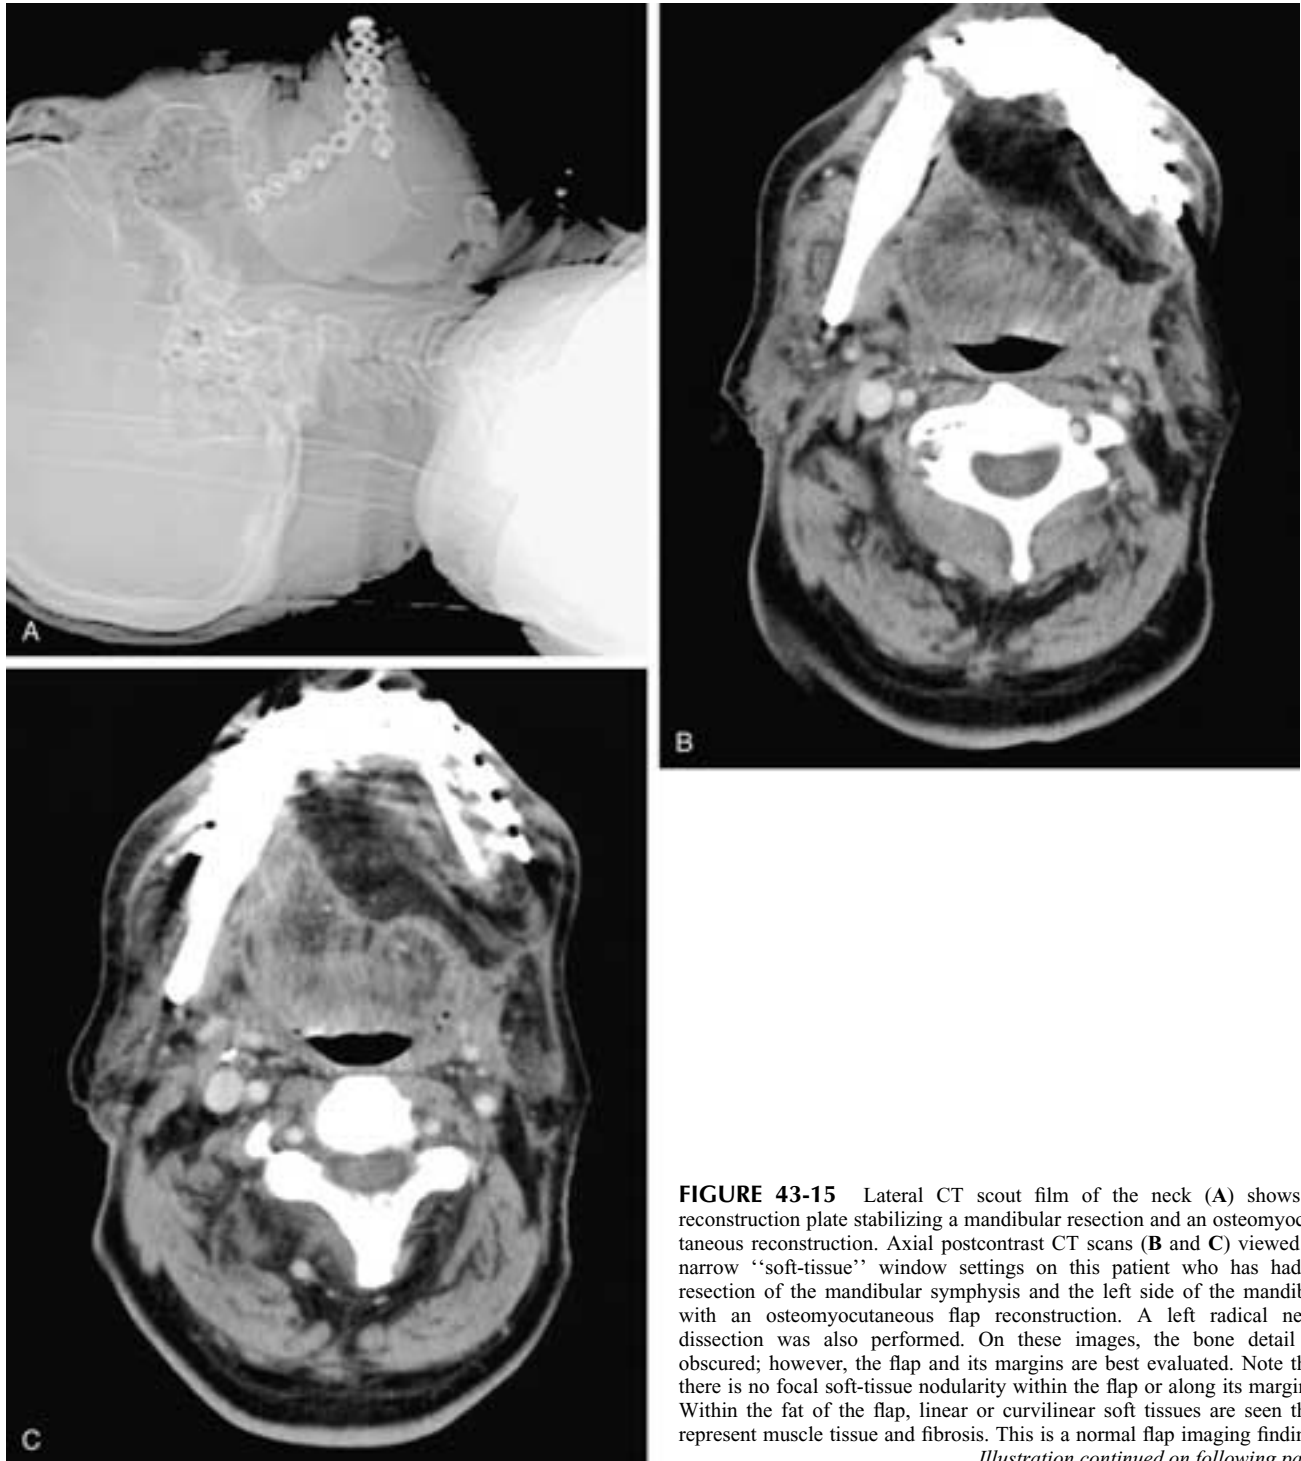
Lateral CT scout film of the neck (A) shows a reconstruction plate stabilizing a mandibular resection and an osteomyocutaneous reconstruction. Axial postcontrast CT scans (B and C) viewed at narrow “soft-tissue” window settings on this patient who has had a resection of the mandibular symphysis and the left side of the mandible with an osteomyocutaneous flap reconstruction. A left radical neck dissection was also performed. On these images, the bone detail is obscured; however, the flap and its margins are best evaluated. Note that there is no focal soft-tissue nodularity within the flap or along its margins. Within the fat of the flap, linear or curvilinear soft tissues are seen that represent muscle tissue and fibrosis. This is a normal flap imaging finding.
